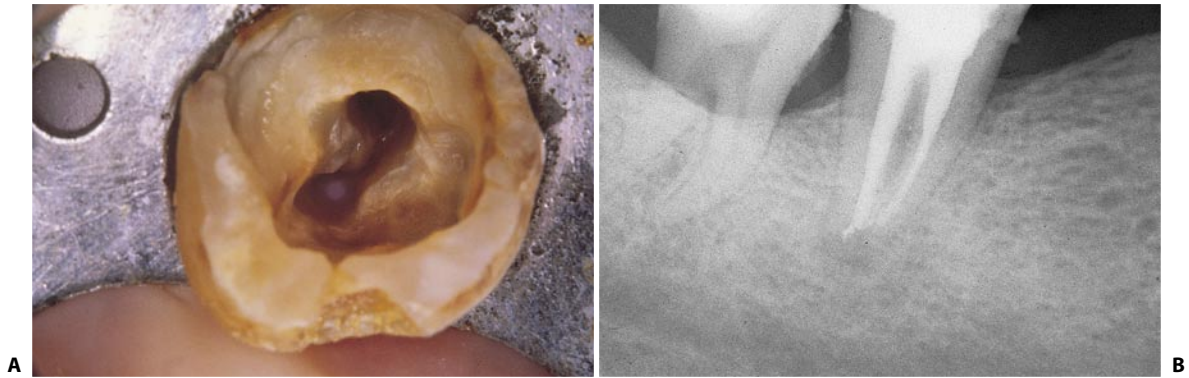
A lower second molar with one canal in the distal root and a single canal in the mesial root. A. Access cavity: the two canals are at the two ends of the shallow groove in the floor of the pulp chamber. On the right, the impression of the bur is recognizable (in a lingual direction). The previous dentist was looking for the non-existing mesiolingual canal. B. Postoperative radiograph: the two canals lie in separate roots, which barely communicate near their apical foramina.
